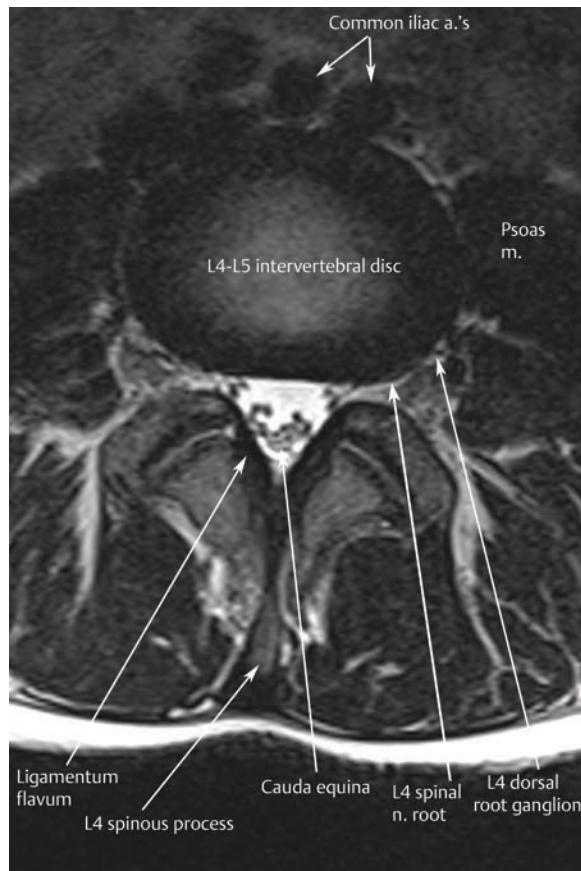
An axial T2-weighted image at the level of the L4-L5 intervertebral disc shows the cauda equina, L4 spinal nerve root, and L4 dorsal root ganglion. Normal flow voids are seen within the common iliac arteries, just below the aortic bifurcation.[†]
